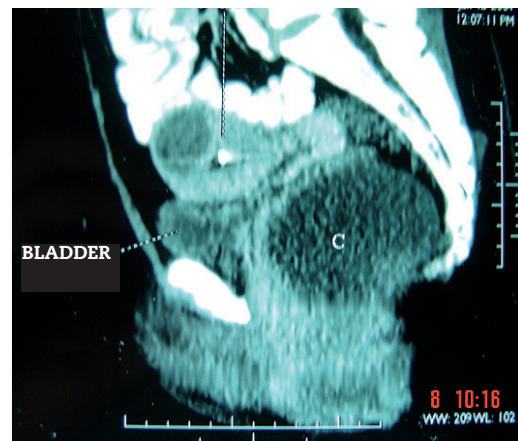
Pelvic CT (sagittal view) showing the presence of mass (C) in the pelvic region.
